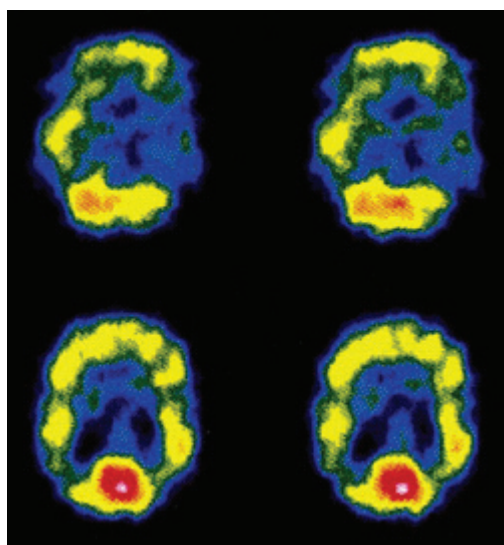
SPECT scan showing blood perfusion.
